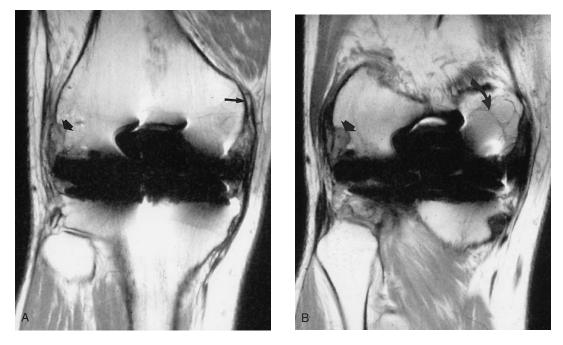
(A) A coronal image of a 43-year-old man with pain and instability taken 8 years after total knee arthroplasty shows a high-grade tear of the proximal medial collateral ligament (long arrow) and absence of the popliteus tendon attachment (short arrow). (B) A slightly more posterior image again shows disruption of the popliteus tendon (short arrow), and a multilobular cystic focus in the posteromedial femoral condyle, consistent with focal osteolysis (curved arrow). The patient subsequently had a total knee revision, at which time a large area of osteolysis in the posterior aspect of the medial femoral condyle, with loss of almost the entire posterior femoral condyle, was seen and grafted. Conventional radiographs failed to show the lesion.
